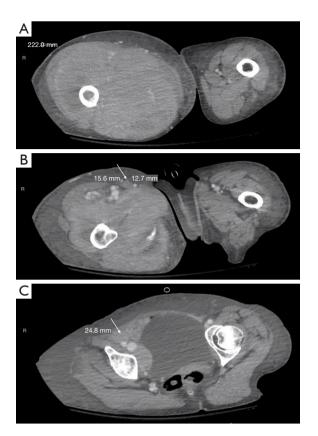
Abdominal CT images show severe soft tissue swelling in the right thigh and enlarged lymph nodes. (A) Images from abdominal CT found severe asymmetrical enlargement of the right leg compared to the left with diffuse subcutaneous edema. On abdominal CT, the presence of an enlarged right inguinal lymph node (B) and right external iliac lymph node (C) were noted, as indicated by arrows in the images. "R" indicates the right side. Dashed lines indicate the sizes of measurements. CT, computed tomography.
